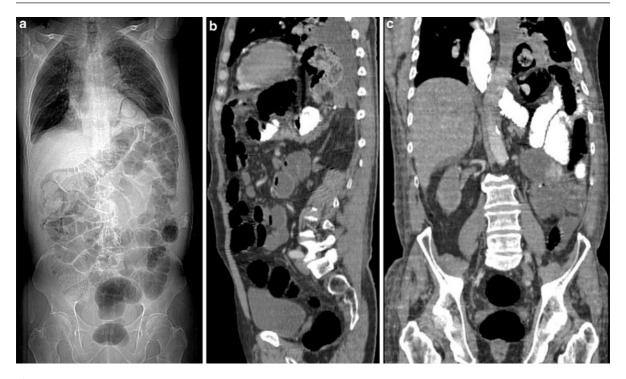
Diaphragmatic hernia: Computed tomography scout view of a CT of the chest, abdomen and pelvis (a) with sagittal (b) and coronal (c) reconstructions: The scout view demonstrates a ring like lucency overlying the cardiac silhouette; on the left suggesting the presence of somehow loculated air in this area (a). The coronal reconstruction (c) shows a bowel
